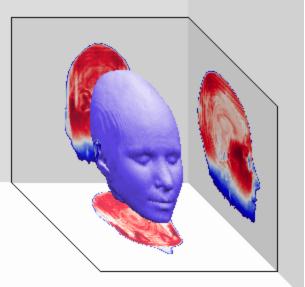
An MRI scan could provide a 3D rendition of the face taken from http://web2.uwindsor.ca/courses/phy ics/high_schools/2006/Medical_Imaging/mri.html)
